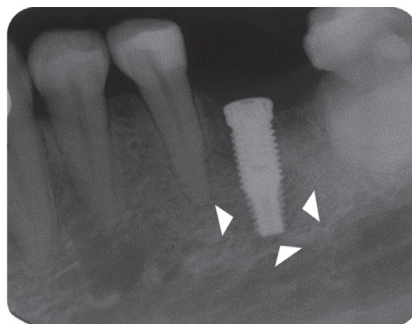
Three weeks after the implant placement surgery, periapical radiographs showed a radiolucent lesion around the apex of the implant and the periodontal ligament widening of the adjacent mandibular left second premolar. Arrow heads depict the extent of IPL.
